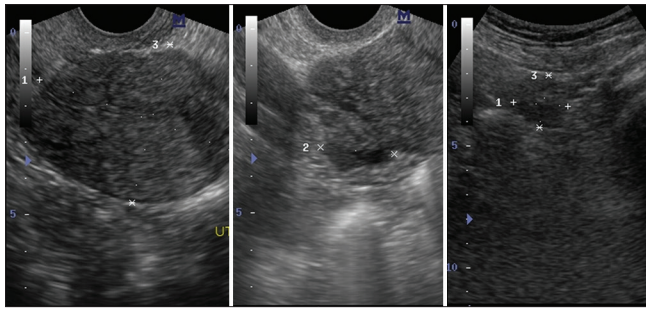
Transvaginal sonogram of Case 2 depicting normal results
